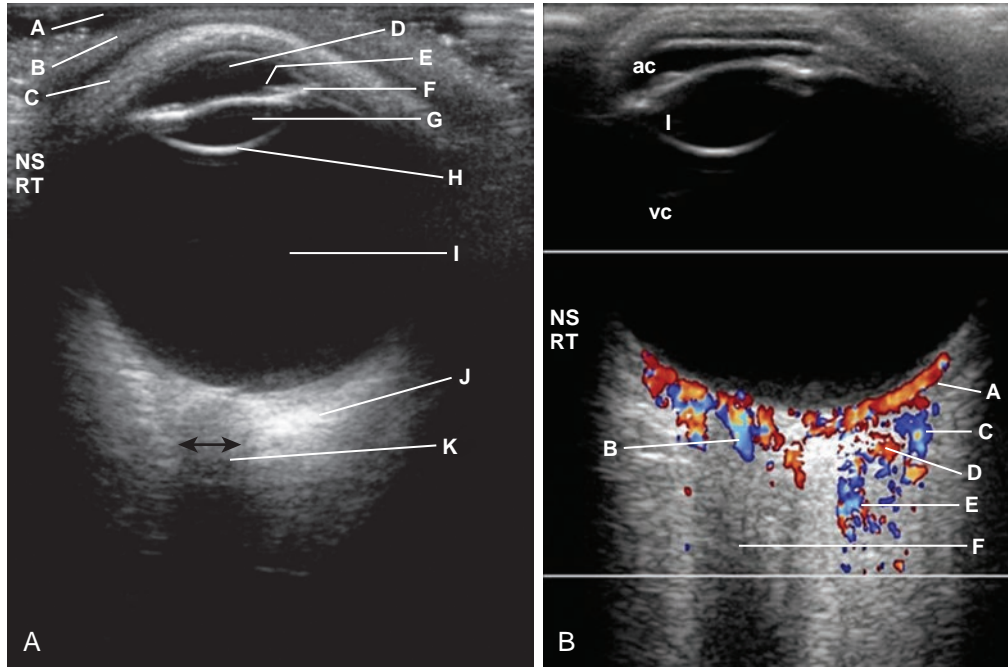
Normal ophthalmic axial ultrasound of a teenager. (A) Using a broadband, high-resolution linear-array transducer (5–17 MHz extended-frequency range), sterile gel (A) is placed on the skin (B) over the upper eyelid (C), which remains shut throughout the examination. The anechoic anterior chamber (D), the iris (E), the ciliary apparatus (F), the anechoic lens (G) with the posterior reflective echo (H), the anechoic vitreous chamber (I), and the hypoechoic optic nerve (J) are demonstrated and the optic nerve width (double-ended black arrow) can be measured. (B) Normal color Doppler examination of the eye in the same patient. Color Doppler imaging shows very good flow in the choroidal vessels (A), central retinal artery (B), lacrimal vein (C) and artery (D), as well as in the ophthalmic artery (E). The anterior chamber (ac), lens (I), and vitreous chambers (vc) are again noted. Different parts of the eye can be examined by having the patient move the eye as instructed. (Courtesy Faridali Ramji, MD.)
